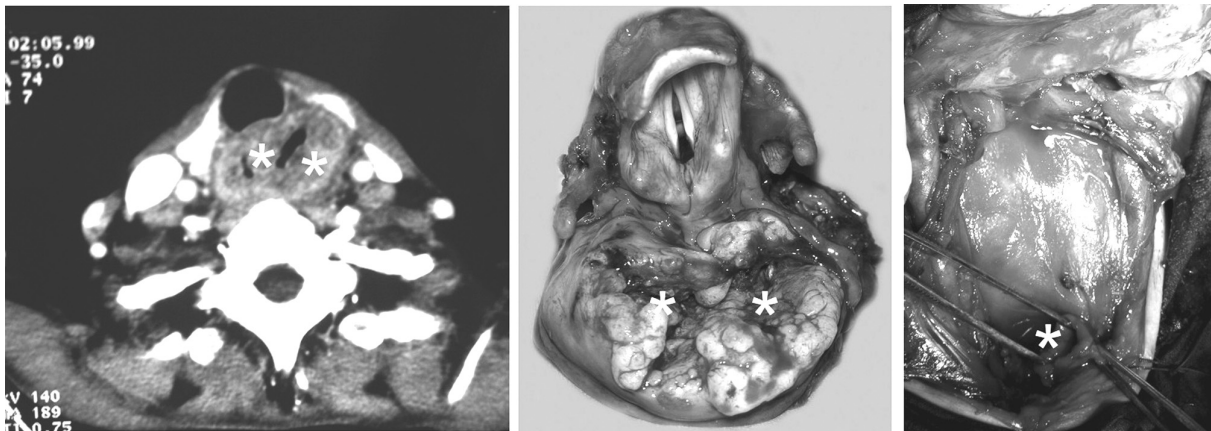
Retrocricoid carcinoma: CT findings, excised tumor with larynx, intraoperative defect with esophagostoma ready for reconstruction.
